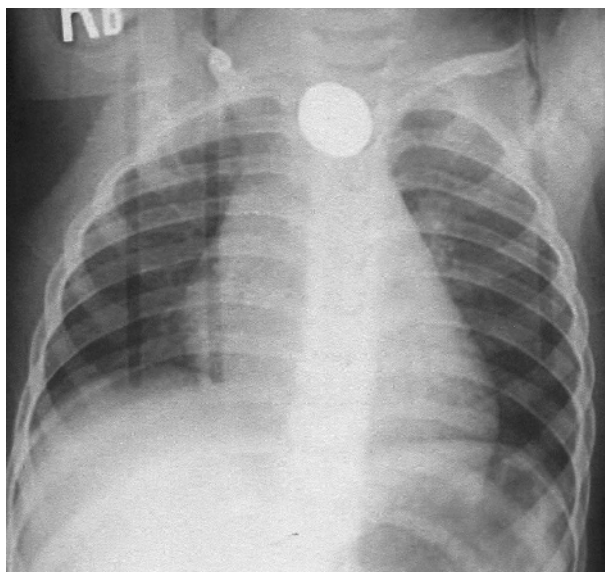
Anteroposterior radiograph of a coin lodged in a patient's esophagus.
